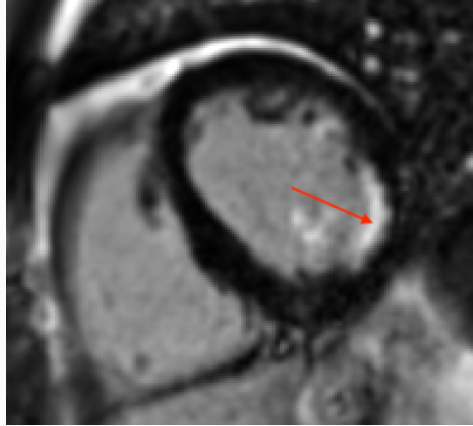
Typical short-axis basal late gadolinium enhancement MRI image with fibrosis (marked with an arrow) as a result of myocardial infarction in the LCx territory in a patient with coronary artery obstructions in LAD, RCA and LCx on angiography
